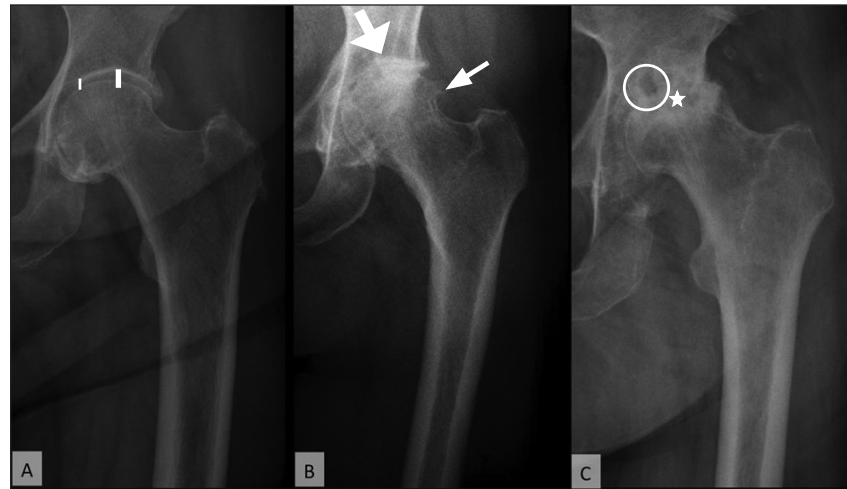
Anteroposterior hip radiograph. A. Narrowing of the superomedial joint space is seen in the region marked by white lines. B. Bone-on-bone osteoarthritis (thicker arrow) with osteophyte formation (thinner arrow). C. End-stage osteoarthritis with femoral head deformation (star) and cyst formation (circle).
